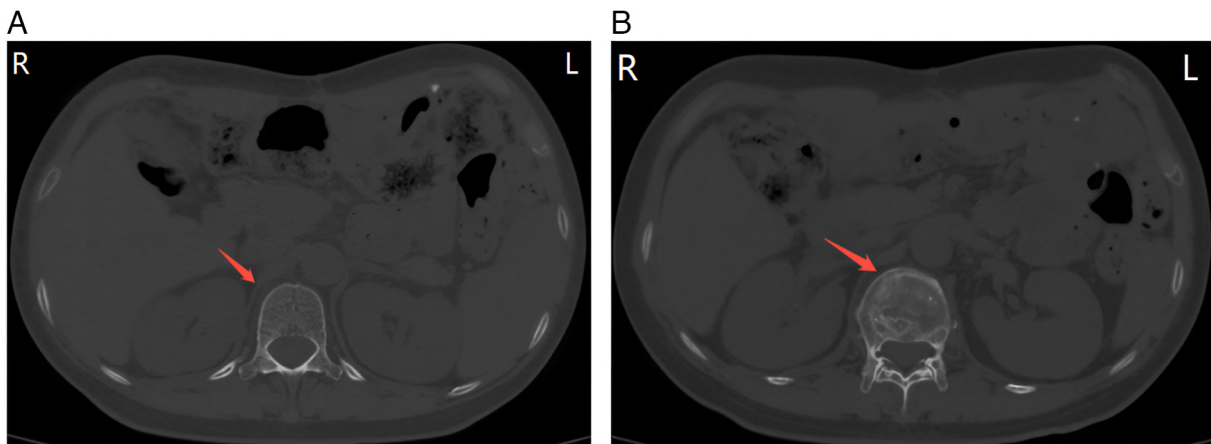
Abdominal plain CT imaging. No significant abnormalities were observed in the (A) T12 vertebral body and (B) L1 vertebral compression fracture.
